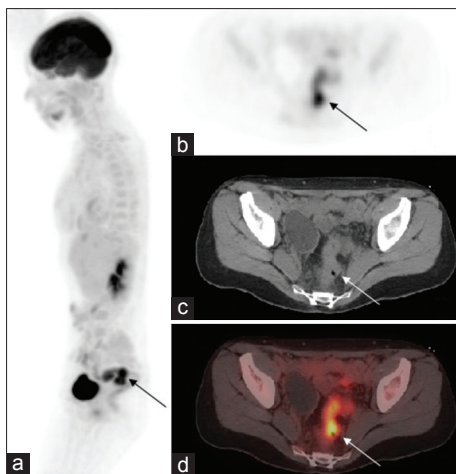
An example of true-positive focal-fluorodeoxyglucose (FDG) colonic activity in a positron emission tomography/computed tomography (PET/CT). (a) FDG-PET/CT maximum intensity projection image showing intensely hypermetabolic wall thickening in the rectosigmoid colon (maximum standardized uptake value 9.6). (b-d) Respectively the (b) FDG images (c) CT images and (d) hybrid images of the malignancy
